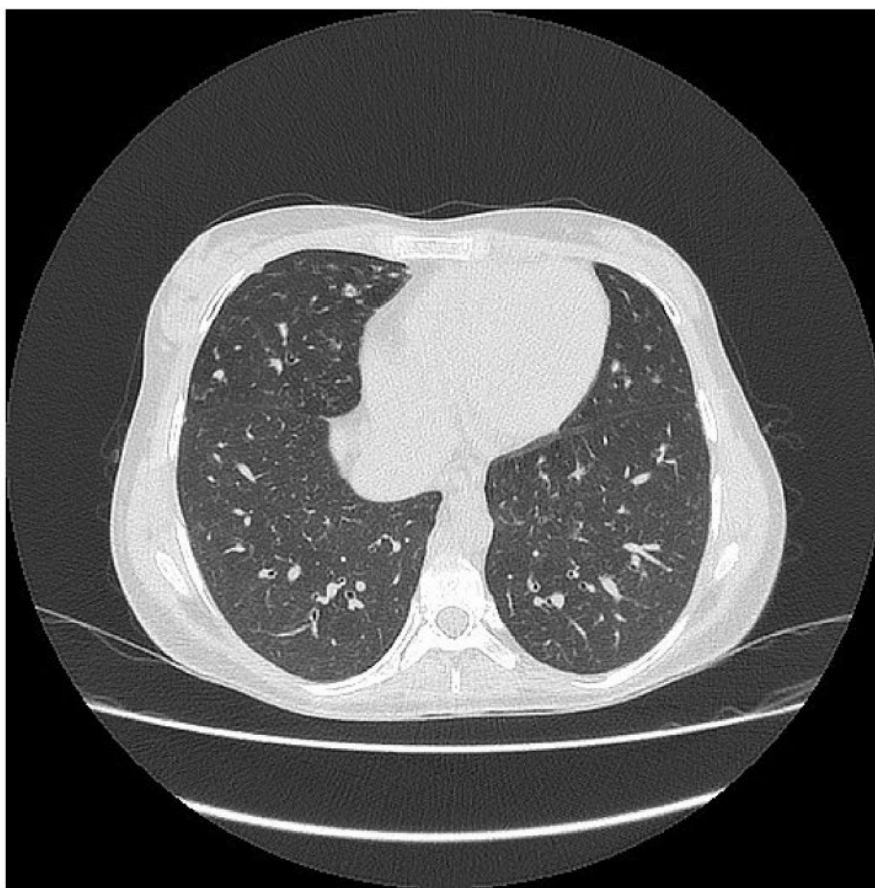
Computed tomography of thorax cavity Signet ring sign typical for bronchiectasis is visible mainly dorsally in both lungs.
